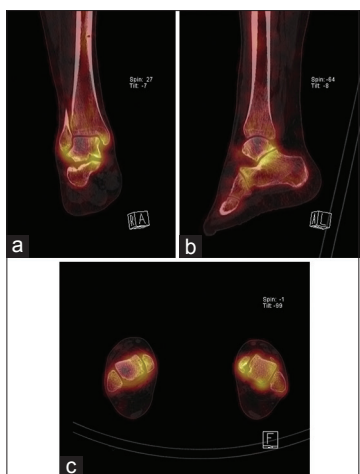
Single photon emission scan/computed tomography images at follow-up (12 months postoperatively) showing signs of avascular necrosis of the superolateral part of the talus and mild anteromedial tibiotalar and posterior subtalar degenerative changes (a) coronal view (b) sagittal view (c) axial view
